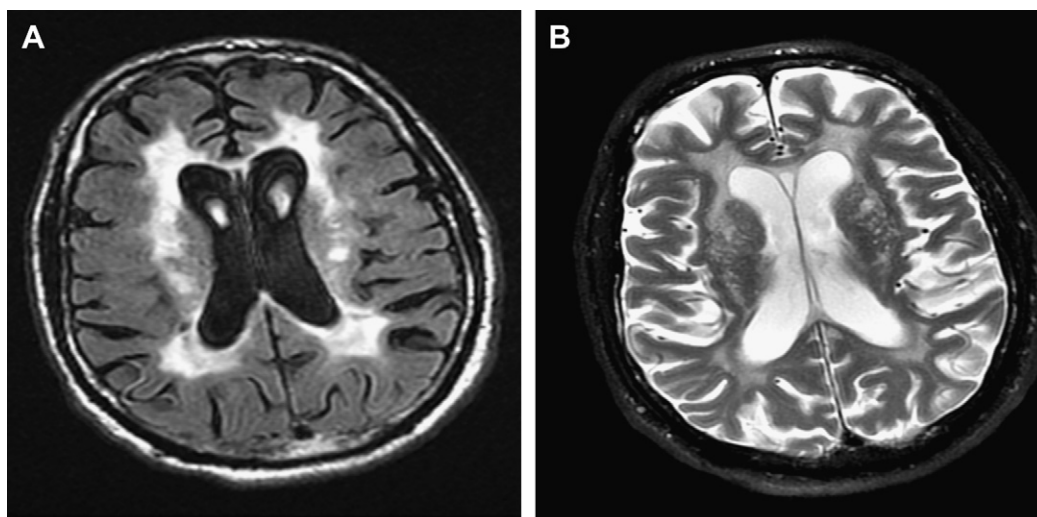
Human immunodeficiency virus encephalitis. FLAIR (A) and T2-weighted (B) MR images demonstrate volume loss and periventricular and deep white matter signal abnormality without mass effect.
